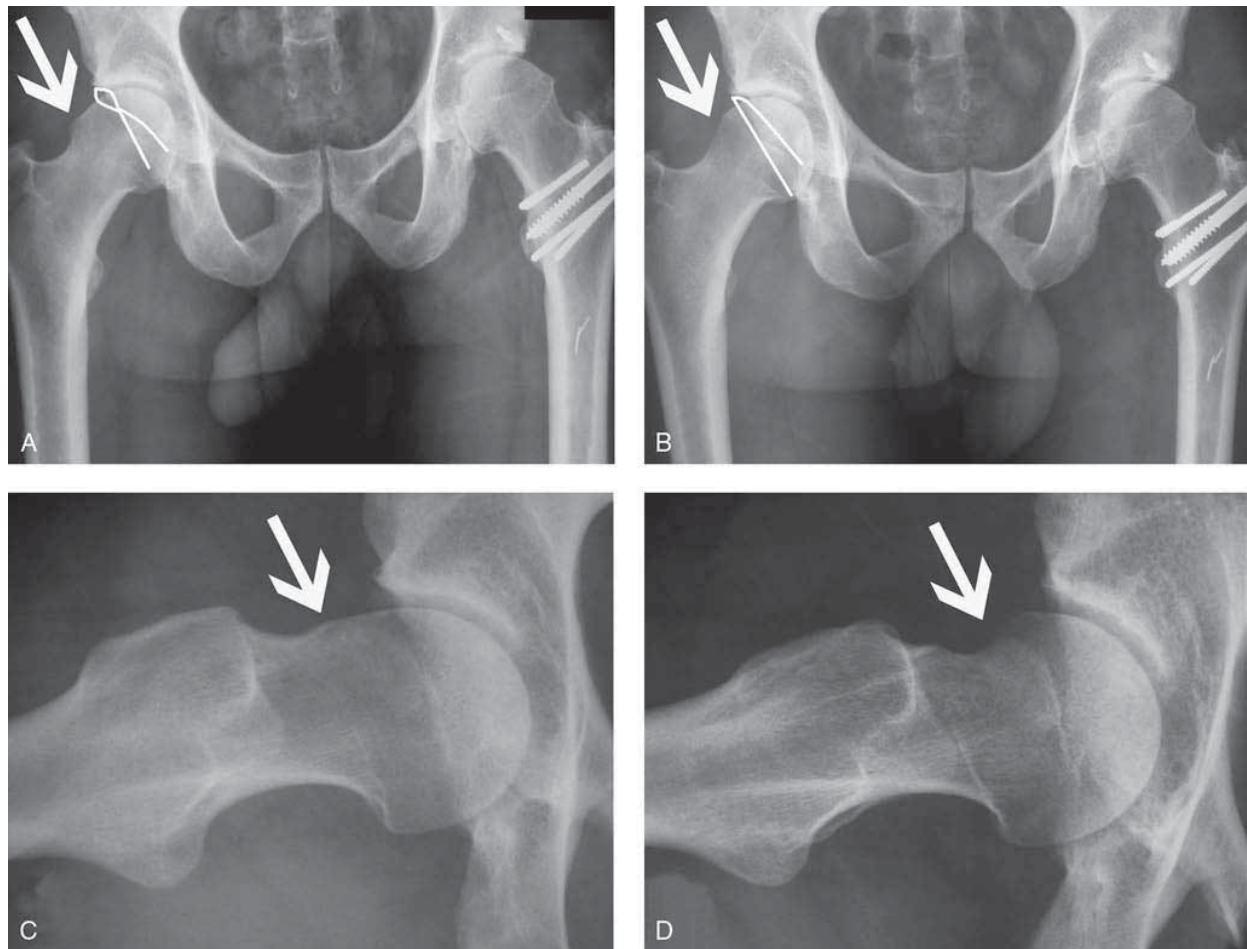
A, A presurgical AP radiograph showing a decreased femoral head-neck offset (*arrow*) and a positive crossover sign (*outline*) in the right hip, consistent with cam and pincer impingement, respectively. The patient had undergone an open procedure on the left hip that was complicated by postoperative trochanteric nonunion. B, A postoperative AP radiograph showing an improved femoral head-neck offset (*arrow*) and absence of the crossover sign (*outline*) after arthroscopic femoral osteochondroplasty and acetabular rim trimming. C, A presurgical frog-leg lateral radiograph consistent with cam impingement (*arrow*). D, A postoperative frog-leg lateral radiograph showing arthroscopic recontouring of the femoral head-neck junction (*arrow*).
